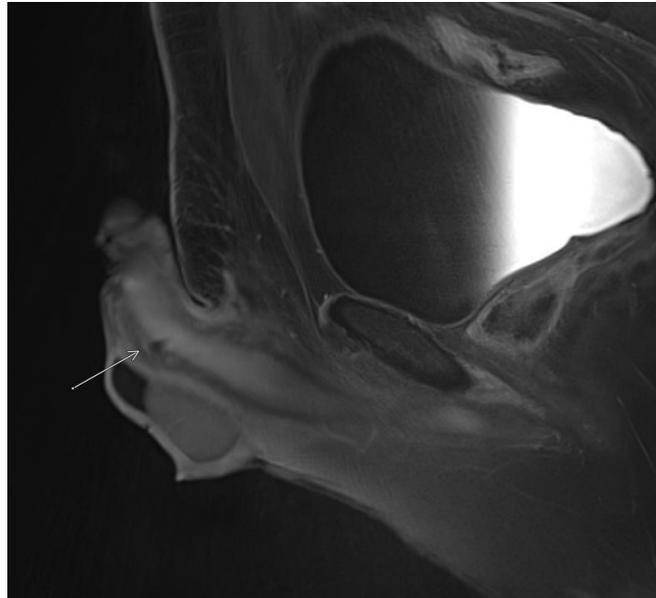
Sagittal MRI Penile Fracture.
